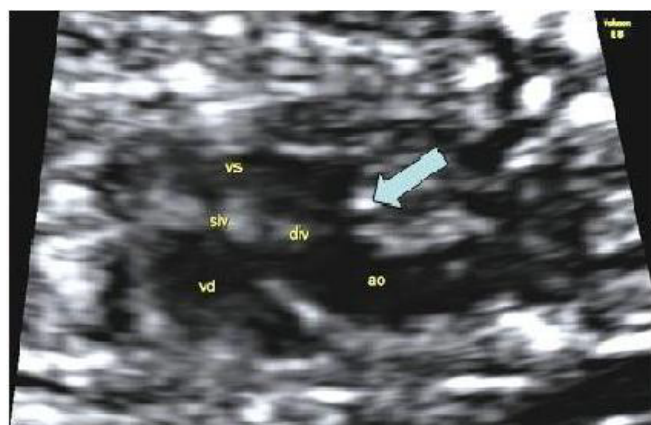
Ultrasound picture of cardiac anomaly of one twin (Tetralogy of Fallot). VS: left ventricle; VD: right ventricle; AO: aorta; SIV: interventricular septum; DIV: interventricular defect (Arrow).
